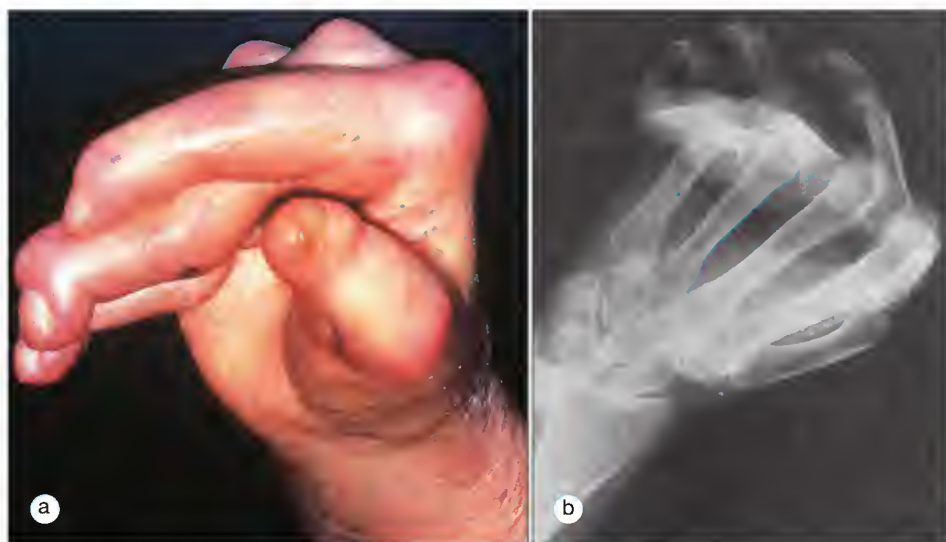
Deforming arthropathy of polymyositis. (a) Rheumatoid-like deformities of the hand in a patient with anti-Jo-1 autoantibody. (b) Radiograph of this patient's hand showing numerous subluxations but minimal bony erosive changes.
